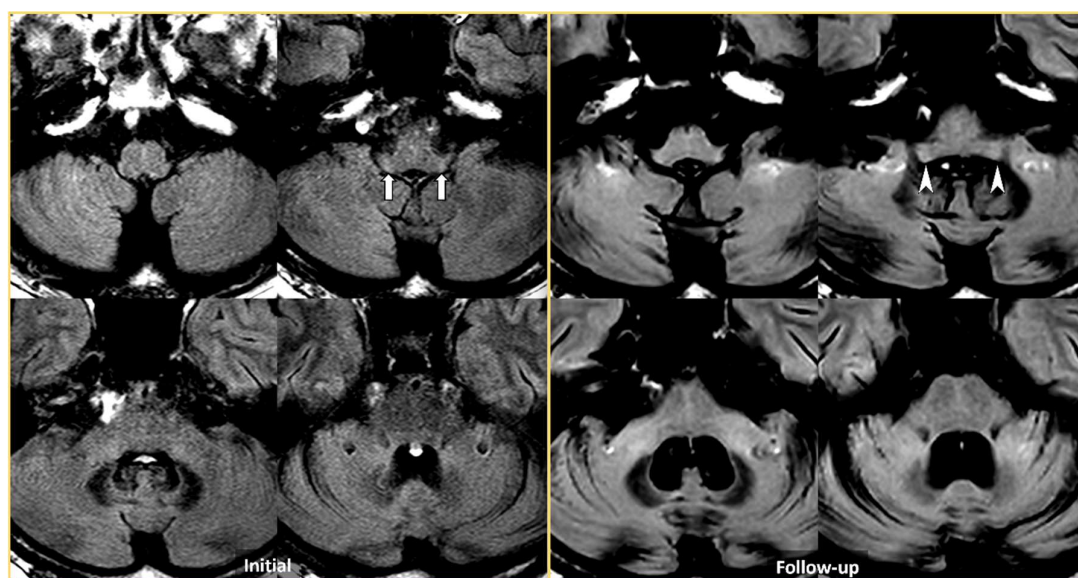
FLAIR imaging in a 53-year-old male who presented with cerebellar ataxia. The initial imaging (left) showed high signal intensity in both inferior cerebellar peduncles (ICPs, arrows), defined as the ICP sign. However, middle cerebellar peduncle (MCP) sign was not evident. On 15-month follow-up MRI (right), the ICP sign was yet again noted (arrowheads) and both the hot
